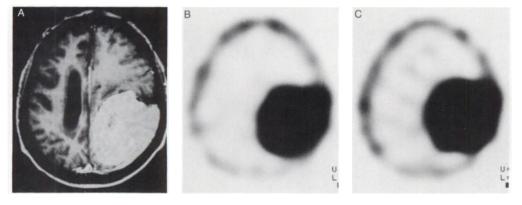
Malignant meningioma. (A) Postcontrast T1weighted MR image shows a large tumor in the left parietal region. Thallium-201 SPECT early (B) and delayed images (C) show high uptake in the tumor. The retention rate is also high. ingioma. This method would also be useful for detecting recurrent malignant meningiomas.
